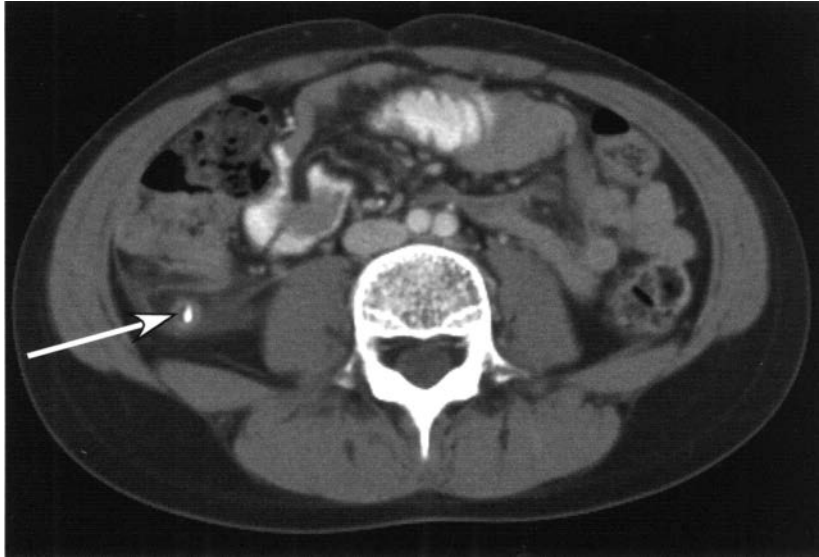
Abdominal CT of a 10-year-old girl demonstrating enlargement of the appendix, some periappendiceal fluid, and an appendicolith (arrow), consistent with acute appendicitis.
